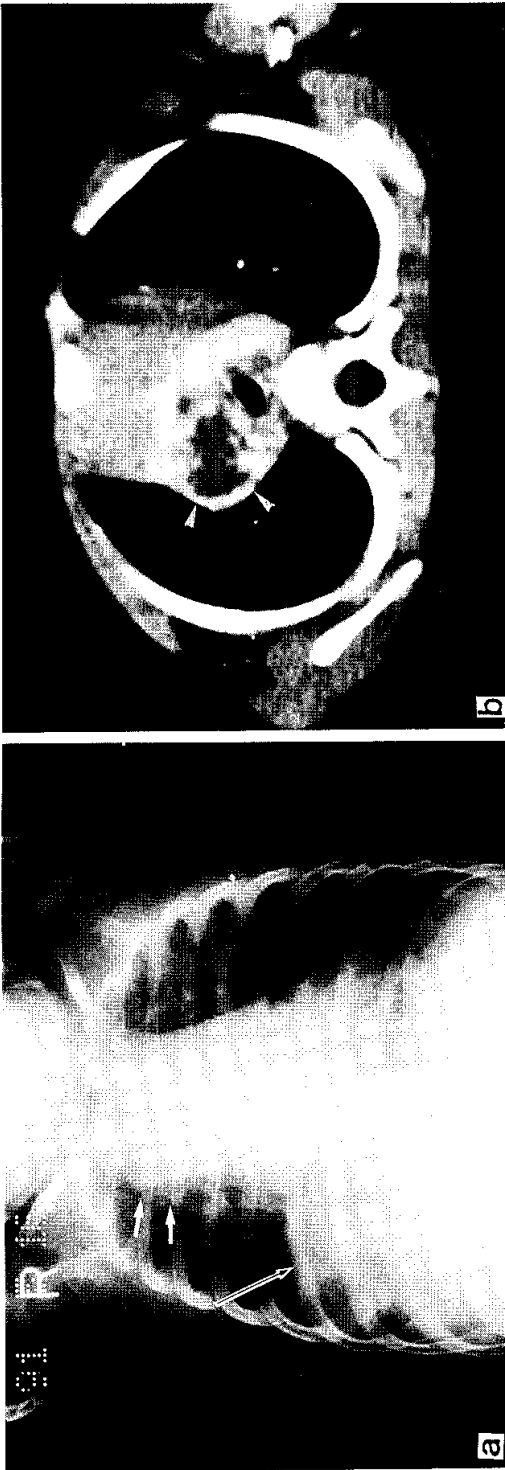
Chest radiograph (A) and CT scans (B,C) obtained after intravenous injection of contrast medium in a 6-year-old boy with primary tuberculosis.
